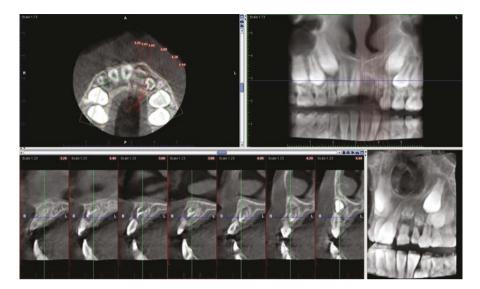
This is a small-field-of-view cone beam computed tomography of a 9-year-old girl with regional odontodysplasia of the permanent left-hand-side maxillary incisors. Notice the ghostlike appearance of both teeth due to poor and aberrant development of enamel and dentine, as well as the fact that the teeth are not erupted and never will
